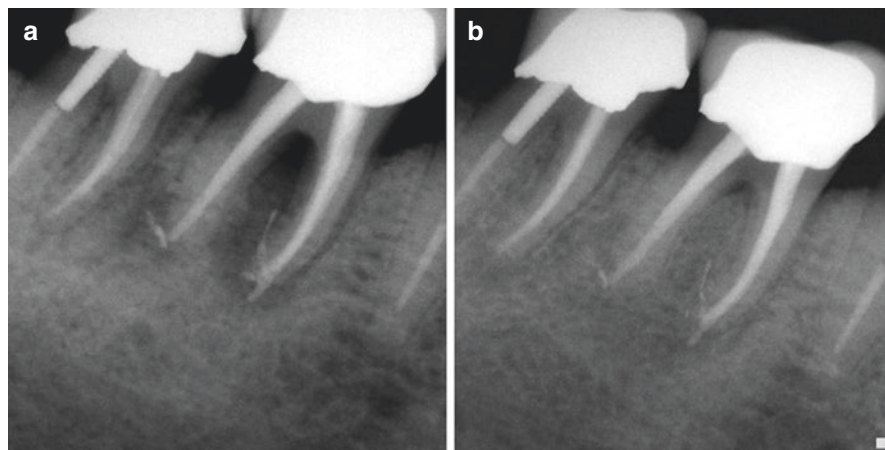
(a) Immediate post-RCT radiograph of tooth #30. Prognosis was questionable due to extensive bone loss and class 2 mobility. (b) 12-month posttreatment evaluation radiograph demonstrating good initial healing. Mobility was reduced and periodontal probings were WNL
